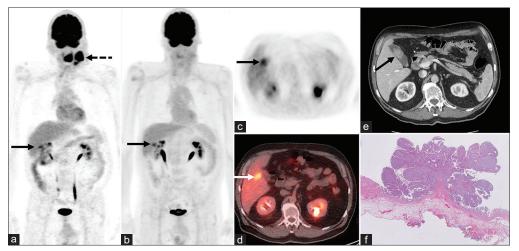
Representative images from whole body f-18-fluorodeoxyglucose positron emission tomography-computed tomography (f-18 FDG PET/CT) scan, the whole body maximum intensity projection (MIP) image, and axial PET and fused axial PET/CT images (a, c, and d), respectively, acquired 1 h after intravenous injection of 11.3 mCi of F-18 FDG. Focal hypermetabolism is seen in the left tonsillar primary and an adjacent left cervical metastatic lymph node dashed arrow in (a). Focal increased uptake is also seen in the right lobe of the liver, segment V with max SUV 5.8 solid arrows in (a, c, and d) raising concern for hepatic metastasis. A targeted chemoradiation regimen was established for presumed metastatic disease. Follow-up FDG PET/CT imaging revealed complete resolution of primary neck tumor and nodal metastasis, and persistent focal FDG avidity within the right hepatic lobe, max SUV of 6.7 arrow in (b). Follow-up CT of the abdomen and pelvis with IV contrast revealed an enhancing, frond-like 3.3 cm mass in the gallbladder lumen arrow in (e). Differences in apparent malignancy location are likely due to misregistration effect between the PET and CT images. Pathology evaluation after laparoscopic cholecystectomy further revealed noninvasive epithelial proliferation with a papillary configuration, consistent with an intracholecystic papillary neoplasm of the gallbladder (f). Different phenotypes (such as intestinal, gastric foveolar, and biliary) were present in one tumor with no evidence of high-grade dysplasia
